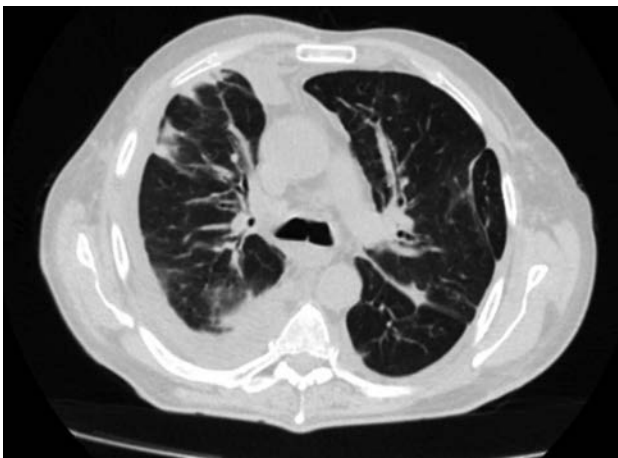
Pulmonary CT: bilateral pleural effusion; thickening of the intra- and inter-septa; the collapse of the right lung
